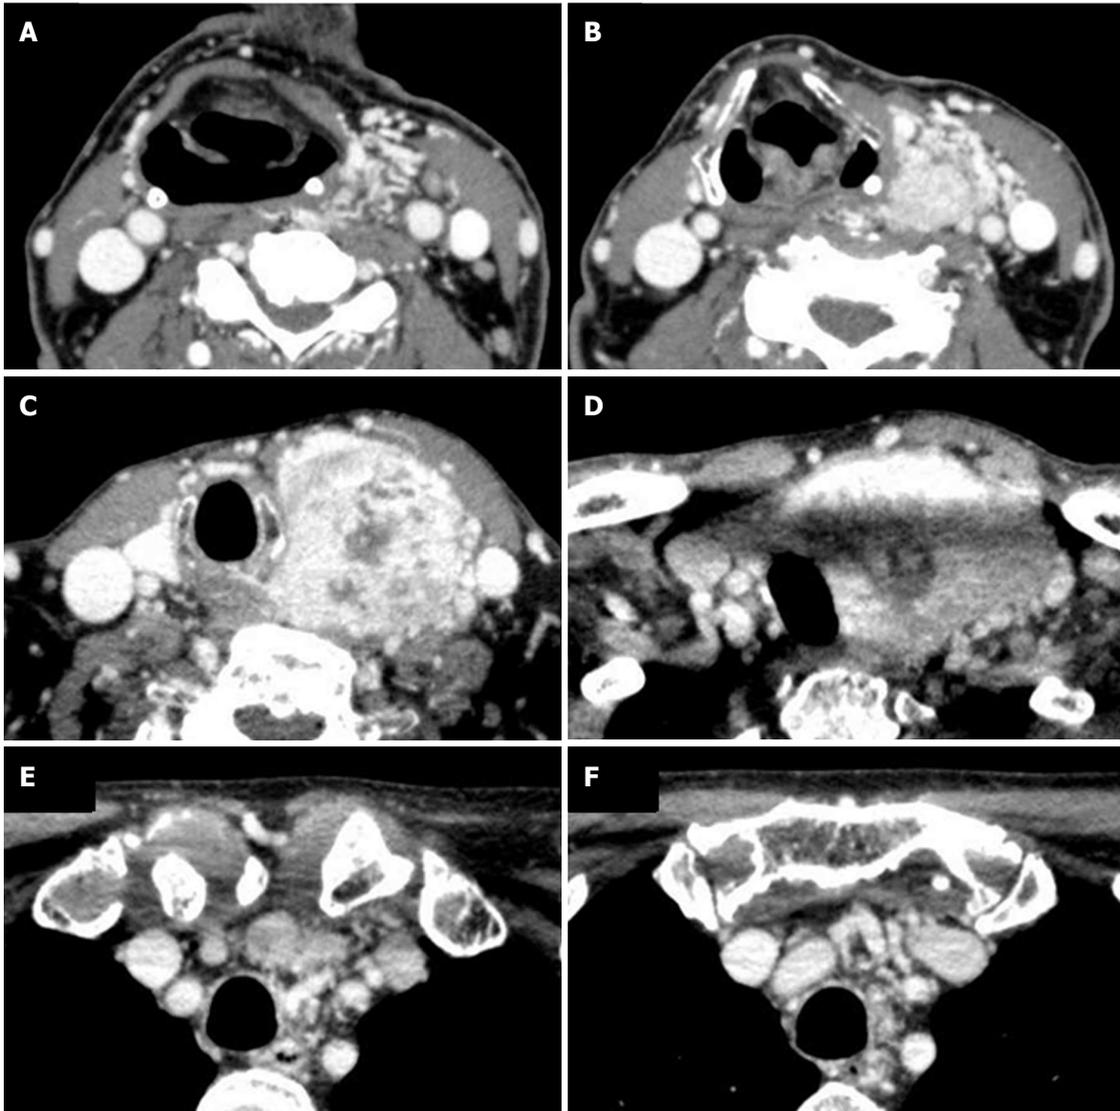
Serial (A-F) contrast-enhanced computed tomography scan images of the thyroid mass 43 mo after the first examination. The computed tomography scan reveals a heterogeneously contrast-enhanced large tumor surrounded by various vascular-like structures. The trachea was compressed but invasion was not apparent.
